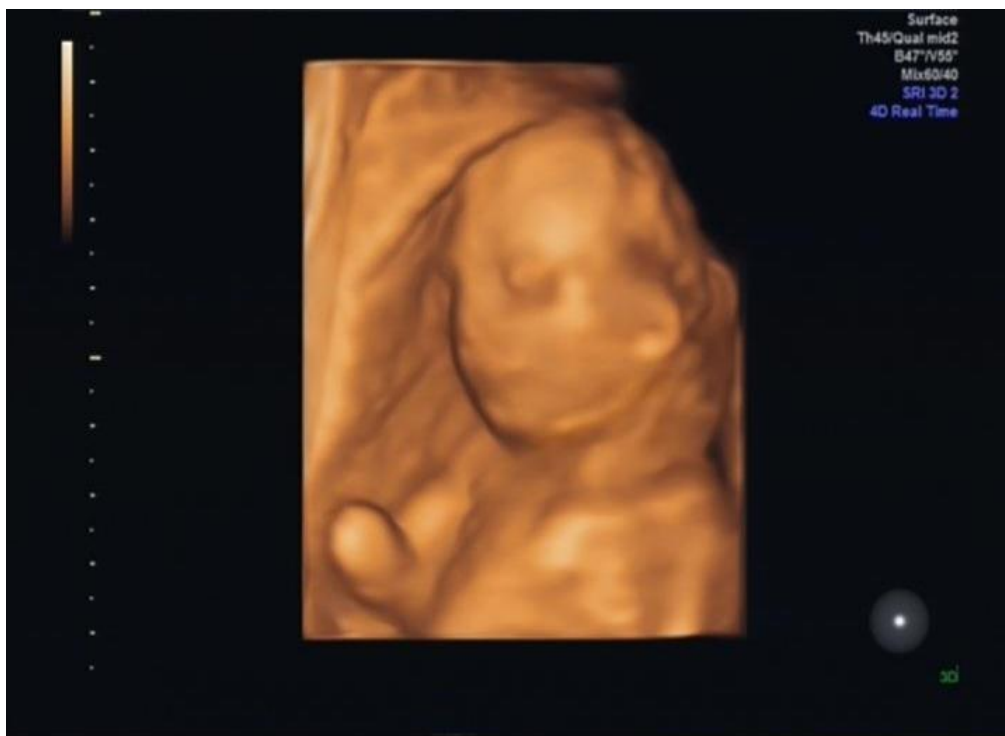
4D Real Time ultrasound examination: Mandibular hypoplasia.
